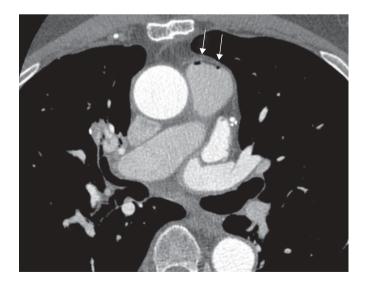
Incidentally found air-emboli on cardiac computed tomography (CT) in an asymptomatic 62-yr-old male. Axial contrast-enhanced CT image shows multiple small air bubbles in the main pulmonary artery (arrows).
